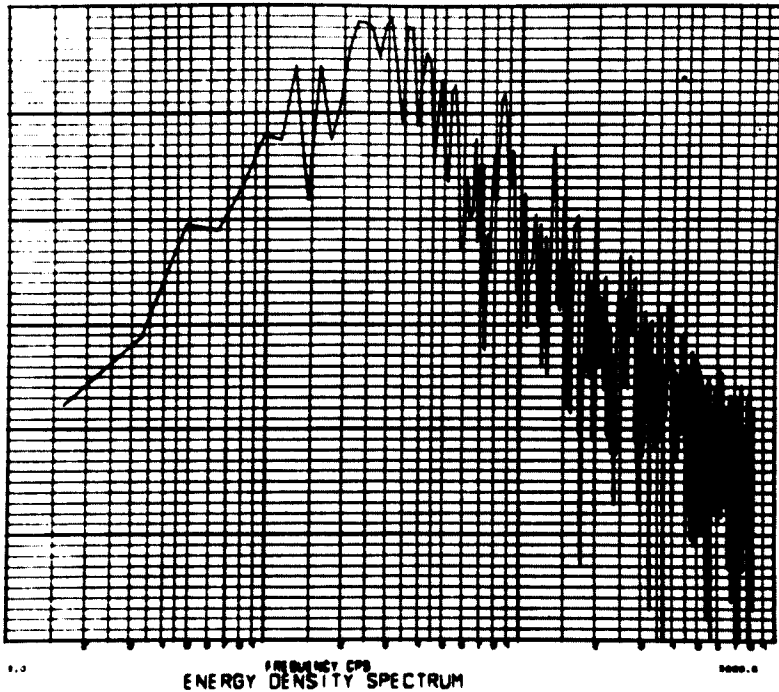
Energy density spectrum analysis of the burbling sounds recorded with the ultrasound flowmeter during known injection of air. The curve is indistinguishable from the energy density spectrum analyses carried out on the patients during insertion of the femoral component.
